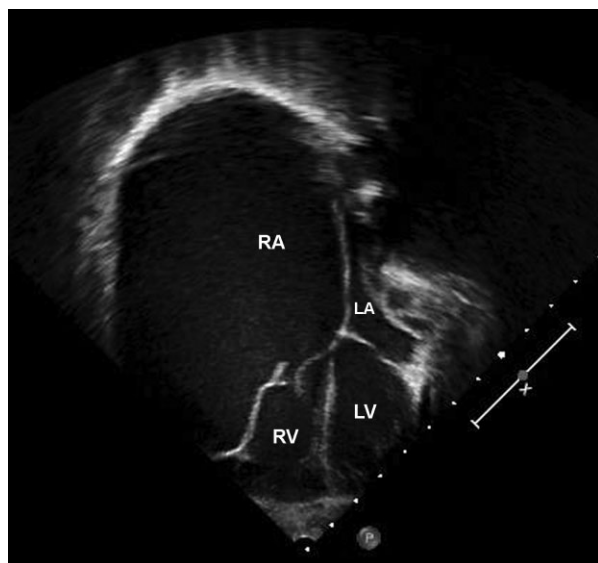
Case 1. Apical four-chamber view demonstrating a massive right atrial aneurysm and left atrial compression. RA, right atrium; LA, left atrium; RV, right ventricle; LV, left ventricle.
